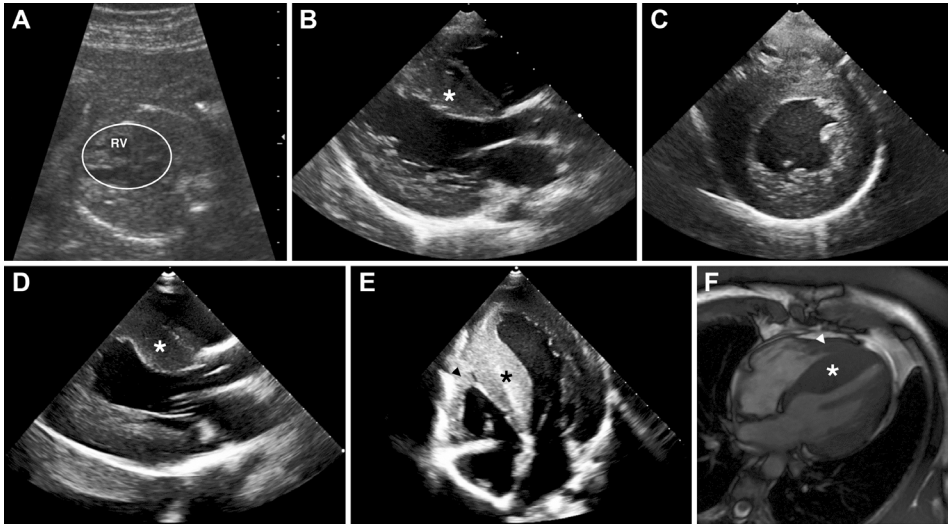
Cardiac imaging in ALPK3-related cardiomyopathy. Prenatal ultrasound performed in patient B-IV:2 at 20 weeks of gestation showed an enlarged heart (encircled) with right ventricular (RV) hypertrophy. (A) Echocardiographic images of the parasternal long-axis (B) and short-axis (C) views in patient B-IV:2 showed severe concentric left ventricular (LV) hypertrophy. Parasternal long-axis (D) and 4-chamber (E) views in patient C-V:2 showed severe concentric LV hypertrophy and moderate RV hypertrophy. (F) Cardiac magnetic resonance image in patient C-IV:2 showed atypical distribution of LV hypertrophy with relative sparing of the basal segments, and RV hypertrophy. Asterisks = interventricular septum, arrowhead = RV hypertrophy. Abbreviations as in Figure 1.
